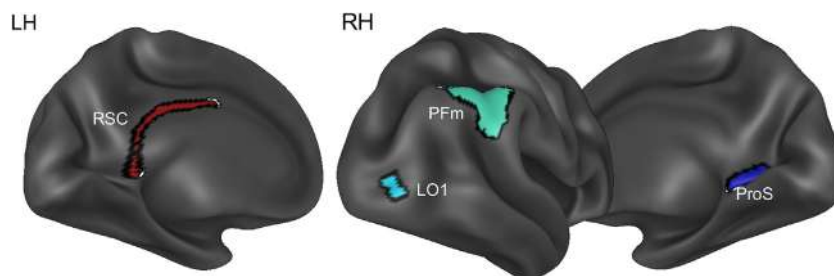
ROIs showing a significant reduced CT in DR. LH = left hemisphere, RH = right hemisphere, RSC = RetroSplenial Complex, LO1 = Lateral Occipital Cortex, ProS = Prostriate Cortex, PFM = Angular Gyrus.
